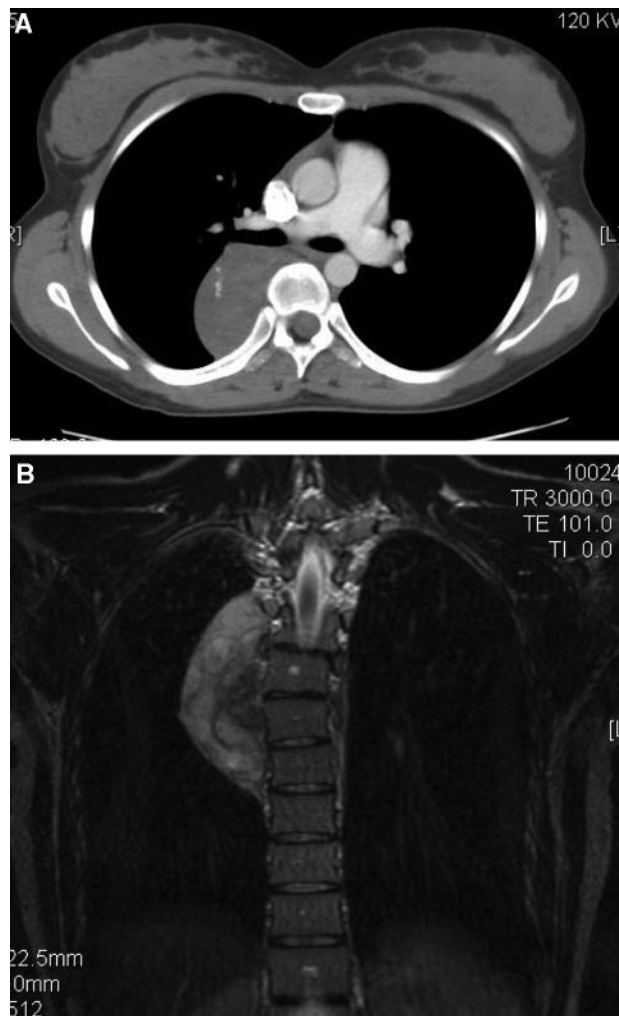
A 20-year-old woman with a posterior mediastinal ganglioneuroma. *Top, A:* a contrast-enhanced CT scan image that shows a mass with mixed attenuation and calcifications. *Bottom, B:* acoronal T2-weighted magnetic resonance image that shows an 8-cm mass with heterogeneous signal intensity.
